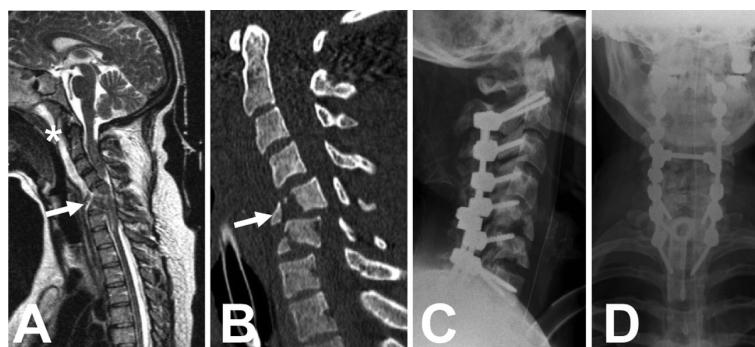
Imaging of human spinal cord compressive injury. (A) Sagittal view of the cervical spinal cord on magnetic resonance imaging demonstrating the dislocated C5 and C6 vertebra compressing the spinal cord (arrow). The formation of a haematoma ventral to the spinal column C1-C4 indicates possible ligament damage (asterisk). (B) Closer view of the damaged C5 and C6 cervical vertebrae on computed tomography scan, clearly showing bony damage of the vertebrae (arrow). (C) Conventional X-ray lateral view of the cervical spinal column after dorsal stabilization from C2 to Th2. Because of the damage to tendons and vertebrae stabilization surgery needs to be implemented in a large number of cases of SCI. (D) Conventional X-ray antero-posterior view of the same patient with stabilized cervical vertebrae as in panel C.
